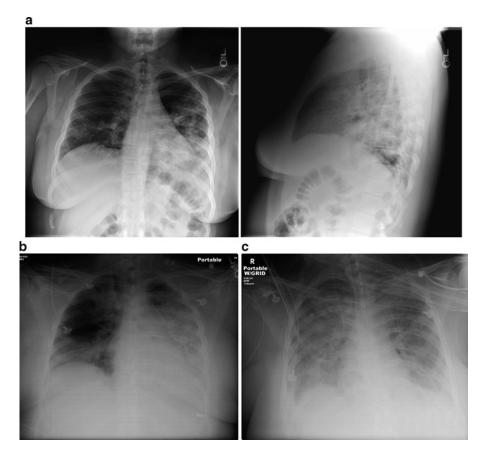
Progression of near-fatal asthma with H1N1 confirmed pneumonia to frank adult respiratory distress syndrome in a 25-year-old woman with asthma and obesity. (A) Chest X-ray (CXR) posterior-anterior and lateral views upon arrival to the ICU from the Emergency Department. (B) Progression of left lower alveolar densities to involve left upper lobe and right lower lobe. Endotracheal tube inserted for mechanical ventilation. (C) Bilateral diffuse air space densities. The patient expired despite critical care support and ECMO.
